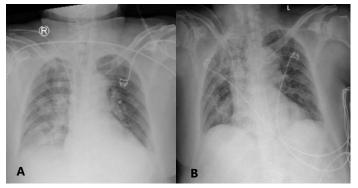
Thorax X-ray before IVIG. A) day 1 of IVIG, B) day 4 of IVIG
